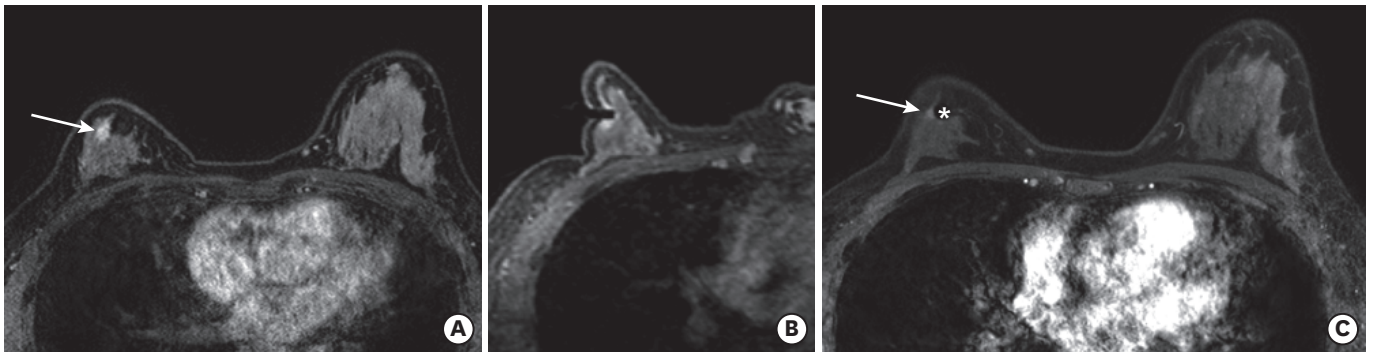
A 35-year-old premenopausal woman with a concordant benign result after a MRI-guided biopsy. (A) Axial T1-weighted fat-suppressed contrast-enhanced MR images obtained from the ipsilateral breast of the previous breast-conserving surgery show focal non-mass enhancement in the right upper outer quadrant on the early phase image (arrow). The lesion is categorized under BI-RADS 4B. (B) MRI-guided VAB was performed, and a marker was inserted at the biopsy site. The result was fibroadenomatoid mastopathy. (C) After 1 year, the lesion (arrow) around the marker (asterisk) decreased in size. MRI = magnetic resonance imaging; MR = magnetic resonance; BI-RADS = Breast Imaging Reporting and Data System; VAB = vacuum-assisted biopsy.
